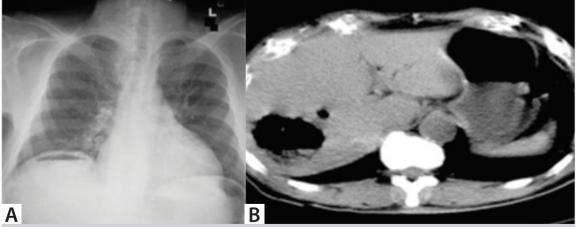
A. Chest radiograph showing pneumoperitoneum. B. CECT of the abdomen showing two large hypodense space occupying lesions with air specks and air-fluid levels.
